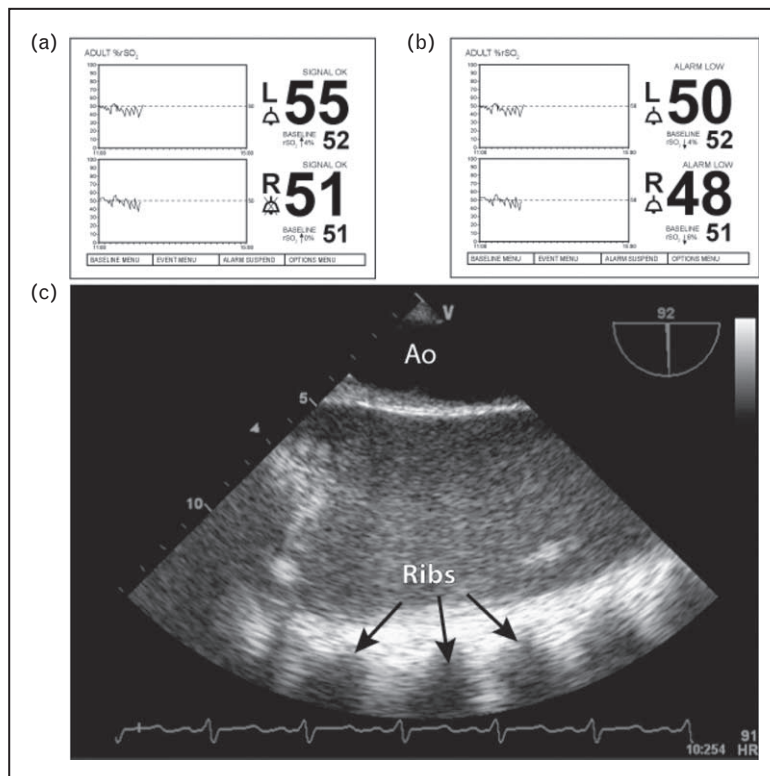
Postcardiopulmonary bypass (CPB) reduction in cerebral near-infrared spectroscopy (NIRS) in a 54-year-old woman undergoing coronary revascularization and resection of an interatrial mass (a, b). The right ventricular pressure waveform was normal at the time (not shown). Significant reduction in hemoglobin from 14.7 to 9.2 g/l was noted. Lung ultrasound examination revealed the presence of a massive hemothorax in the left pleural space. This was most likely from occult bleeding of the left internal mammary artery (c). Ao, aorta (Supplementary Digital Content 3, <http://links.lww.com/COAN/A14>).
